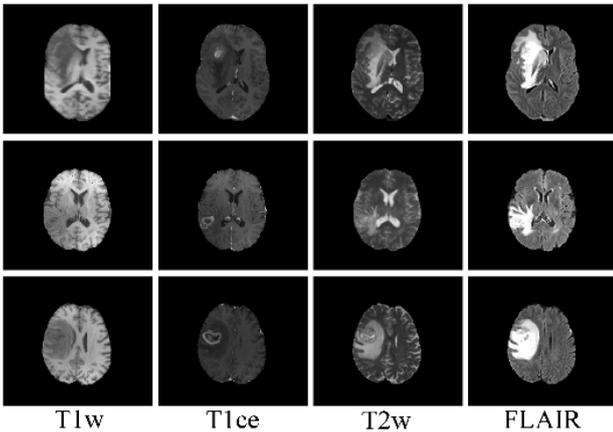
Visualization of brain tumor segmentation across multiple MRI modalities. From left to right: MRI images in four modalities (T1w, T1ce, T2w, and FLAIR) are shown for three different patients.
